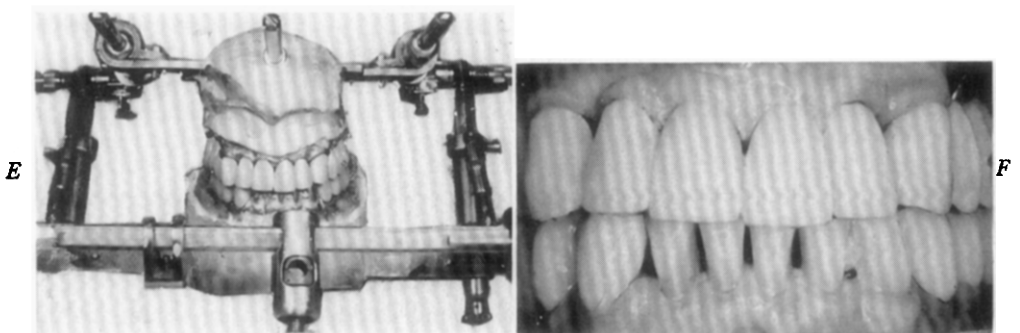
The rehabilitation of a 38-year-old woman with a tendency toward dental prognathism: *D*, the completed prostheses (the upper-incisor porcelain jacket crowns are yet to be constructed [1947]); *E*, before insertion of the porcelain jacket crowns and at completion of treatment (the tip-to-tip occlusion was maintained, as was the original occlusal vertical dimension); *F*, radiographs made 25 years postinsertion (1972). The oral structures were good and have remained good to age 65.
